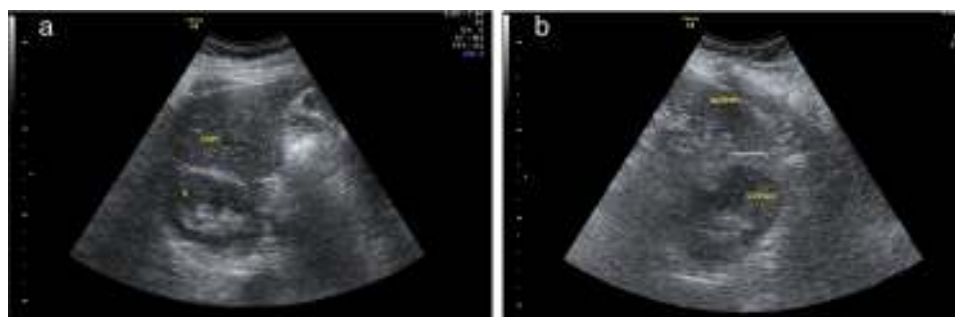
2D ultrasound showing normal both kidneys.
